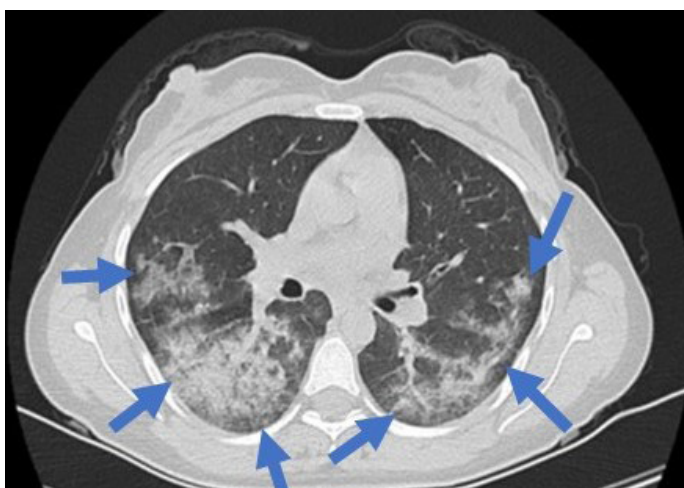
Thorax Computed Tomography: Diffuse alveolar hemorrhage in lung parenchyma
